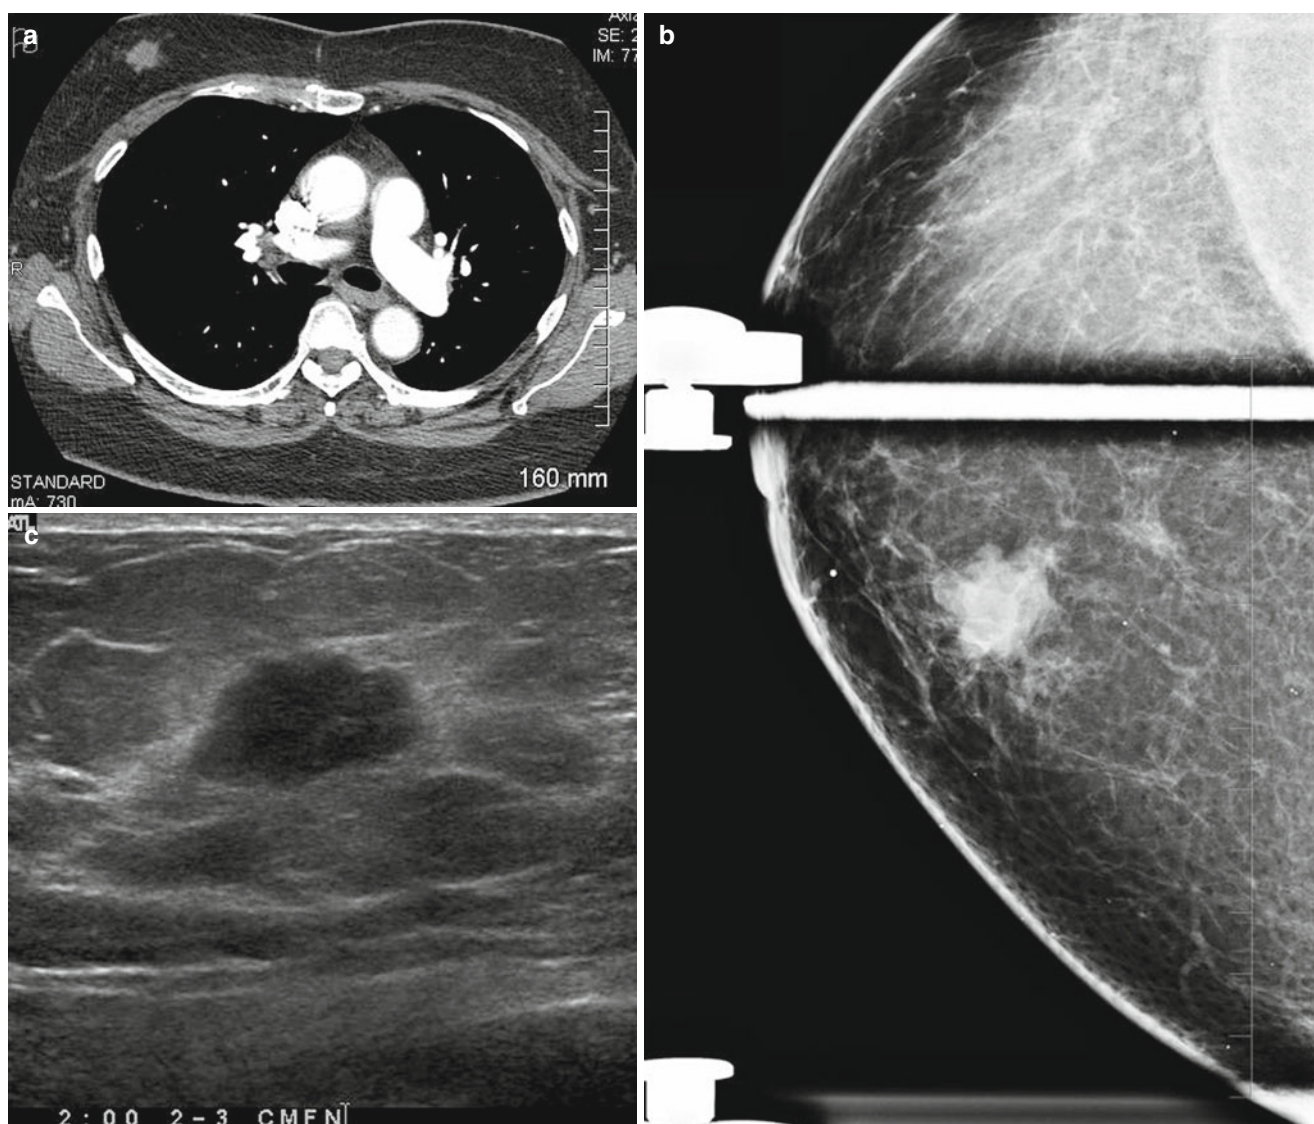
(a–c) A 60-year-old who had not undergone screening mammogram in 4 years. (a) CT pulmonary angiogram performed for chest pain reveals a 2 cm mass in right breast. (b) Spot compression craniocaudal
